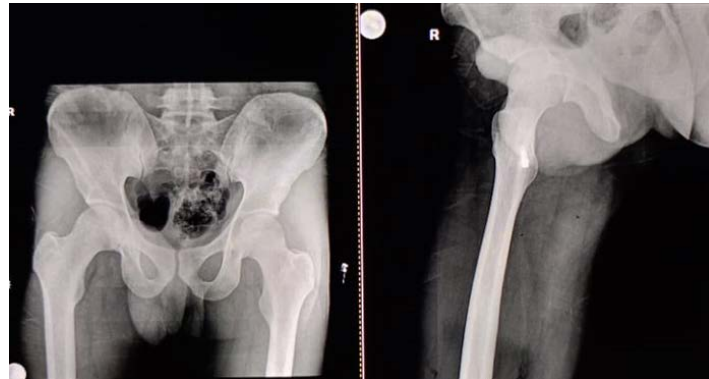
Pistol grip deformity in CAM type of FAI of unilateral painful right hip as clearly seen on anteroposterior and lateral radiographs of 22 years old athlete.
